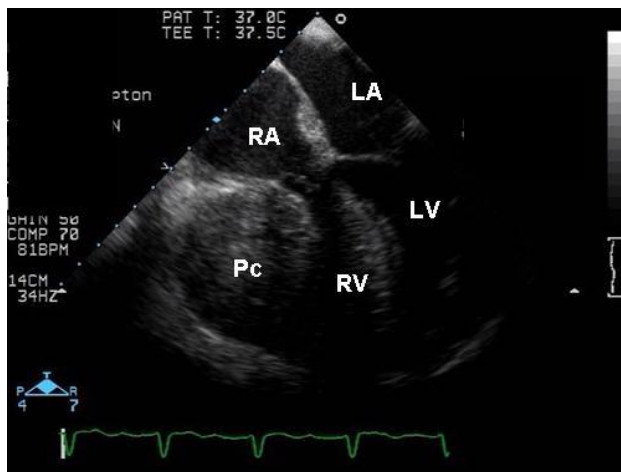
Trans-oesophageal echocardiogram (4-chamber view) in a patient with circulatory collapse 48 hours following cardiac surgery. TTE was negative, with no collection seen, and no echocardiographic features of tamponade documented. Here a large collection (Pc) can be seen compressing the right ventricle which is slit-like.
